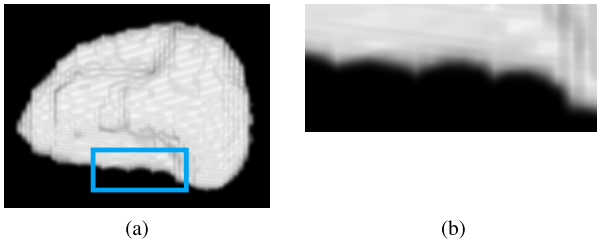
Interpolation by surface diffusion in gaps using an MCF – the modeled object is the left ventricle cavity of a heart reconstructed from a MRI dataset. (a) global view, (b) zoom of the highlighted part of (a).
